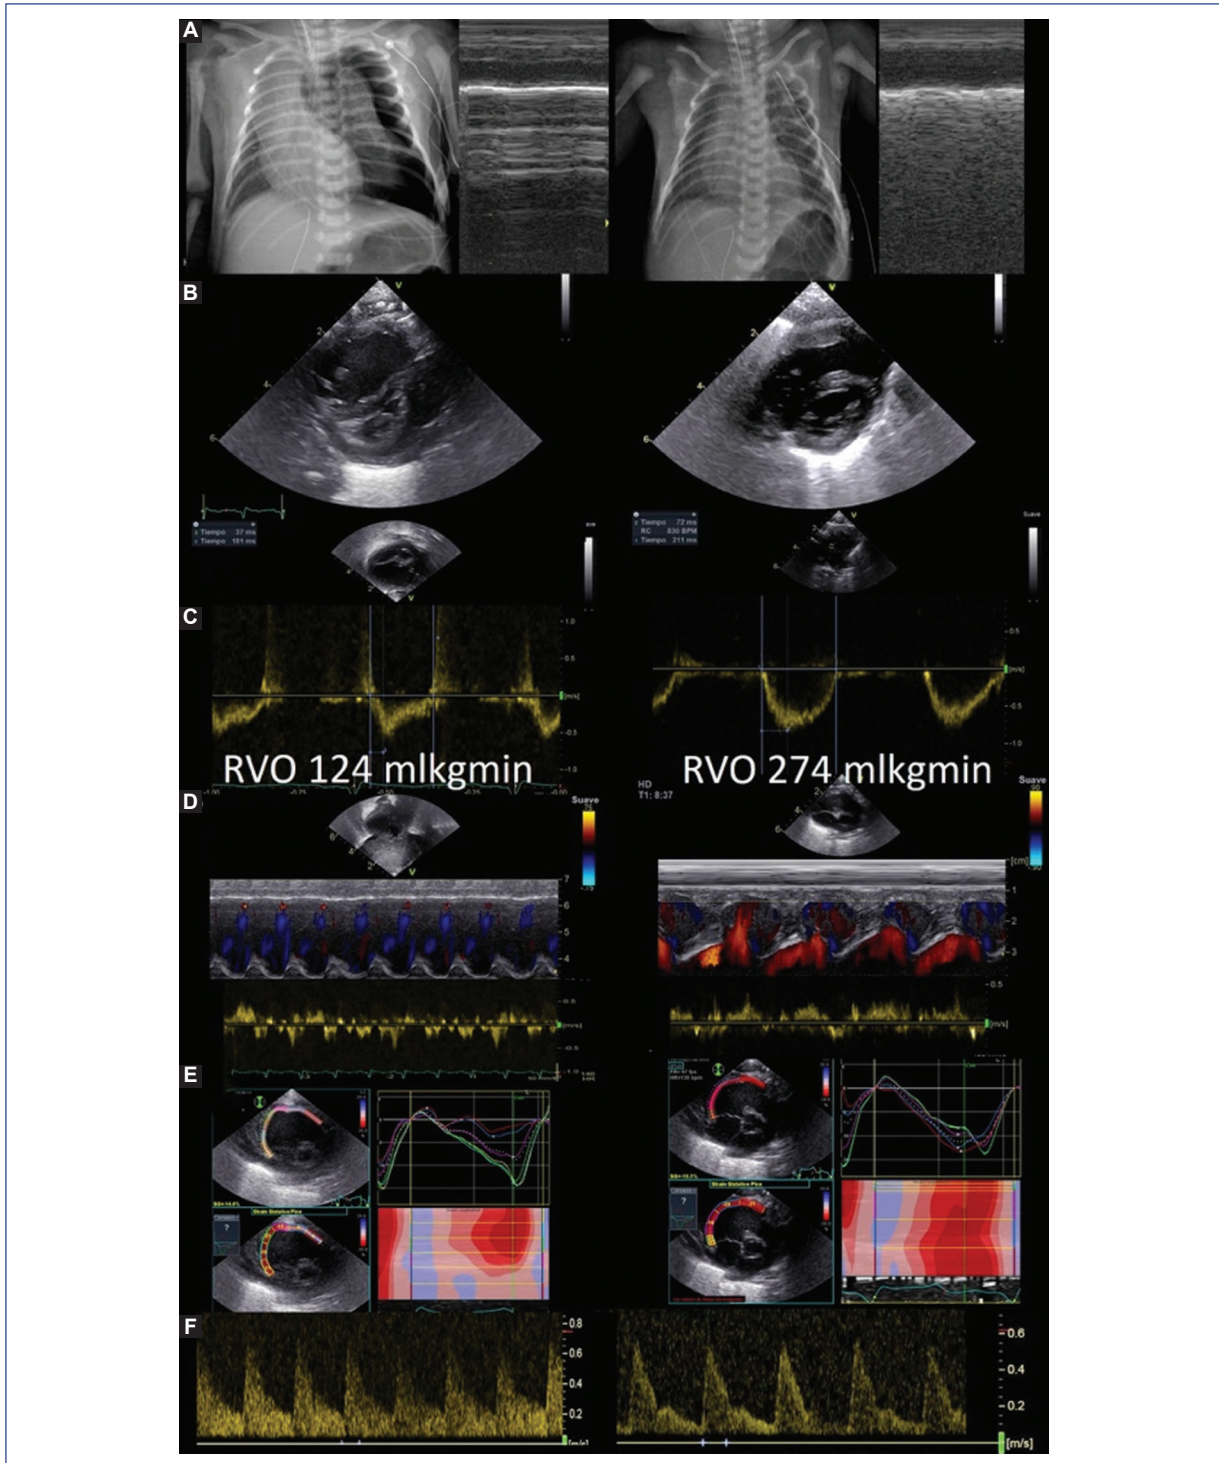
Hemodynamics before and after tension pneumothorax drainage. A: CXR with corresponding LU M-mode comparing tPTX and normal pleural sliding (Stratosphere sign vs Seashore sign). B: paradoxical vs round shaped interventricular septum. C: pulsed doppler of the pulmonary artery showing short PAAT and PVRi (inversely proportional to PVR) that improved after drainage. Low RVO that augmented 55% after drainage. D: color and pulsed Doppler of the PFO showing a right to left shunt at the time of tPTX that turned left to right after one hour. E: RV longitudinal strain improving from -14% (impaired) to -18.3% (almost normal). F: MCA showing compensatory vasodilation and then normal pattern. CXR: chest radiography; RV: right ventricular; LU: lung ultrasound; tPTX: tension pneumothorax; PAAT: pulmonary artery acceleration time; PVR: pulmonary vascular resistance; RVO: right ventricular output; PFO: patent foramen ovale.
